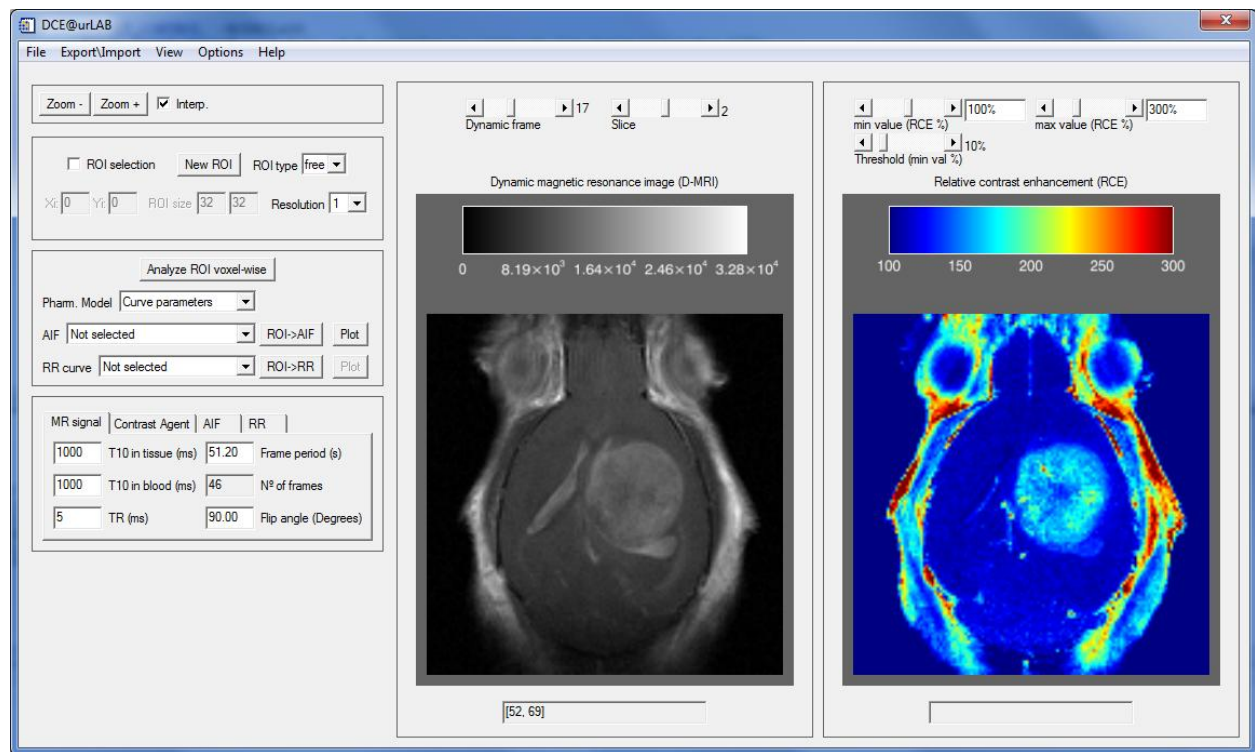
Main graphical interface after loading DCE-MRI data
